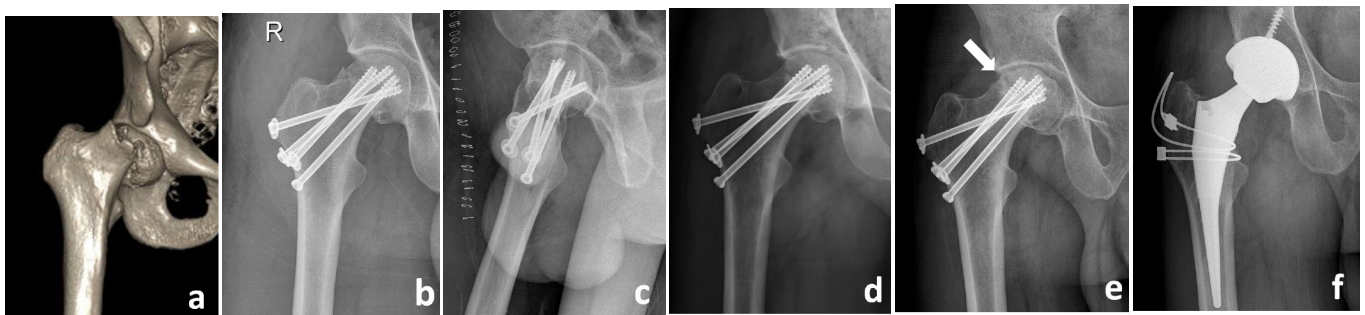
A thirty-three years old male patient with Pauwels' type III fracture a) 3-D reconstructed image shows the nature of the fracture b and c) postoperative radiographs showing fair reduction and fixation with cannulated screws d) Fracture union was achieved at the eighth postoperative month in varus position e) Necrosis of femoral head was evident after 19 months. f) Total hip arthroplasty was performed as revision surgery.
